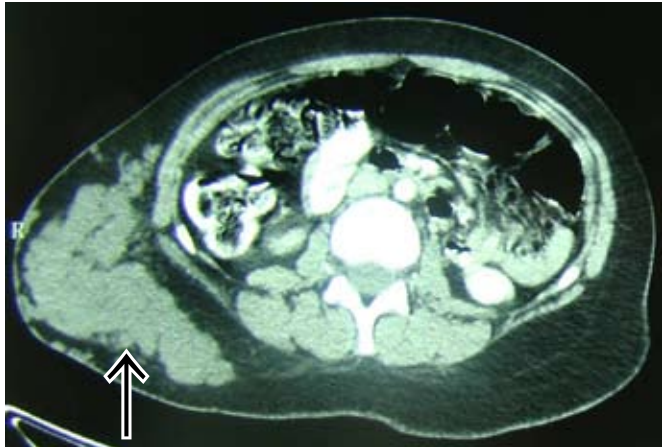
CT scan of a different patient with a large right plexiform neurofibroma causing distortion of the abdominal wall.
